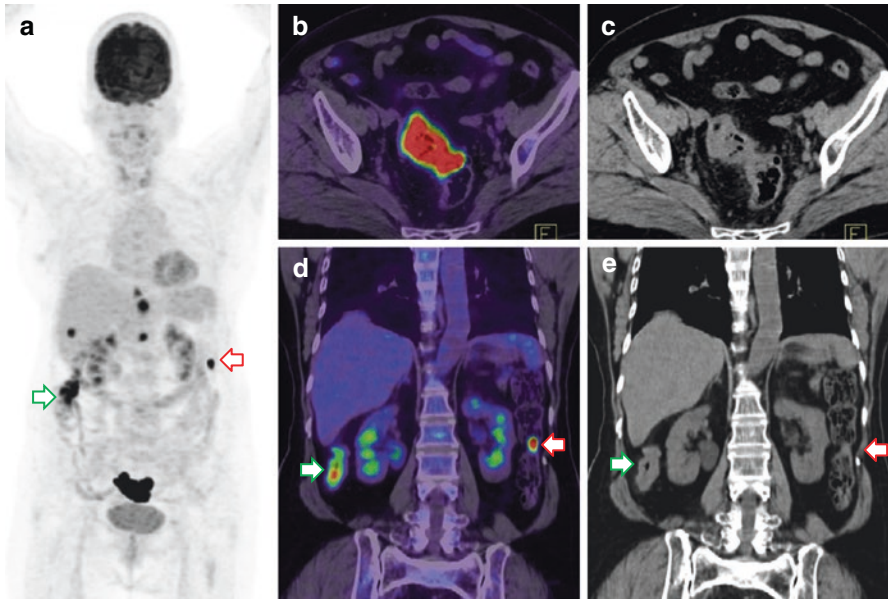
A 71-year-old female with diagnosed carcinoma of the sigmoid colon, 18F-FDG PET/CT (a - MIP) for initial staging showed intense FDG uptake in the sigmoid colon (b - fused PET/CT axial section, c - contrast enhanced CT axial section). Focal abnormal intense FDG uptake (red arrow) was also noted in the mid-descending colon which turned out to be a neoplastic polyp (d - coronal fused PET/CT, e - coronal contrast enhanced CT section). A short segment of intense FDG uptake is noted in the ascending colon (green arrow) with apparent thickening in the unprepared bowel which did not correspond to any abnormality on colonoscopy. Significant FDG uptake in relatively long segments of the colon with no definite mural thickening on CT is often noted without any subsequent abnormality being identified
